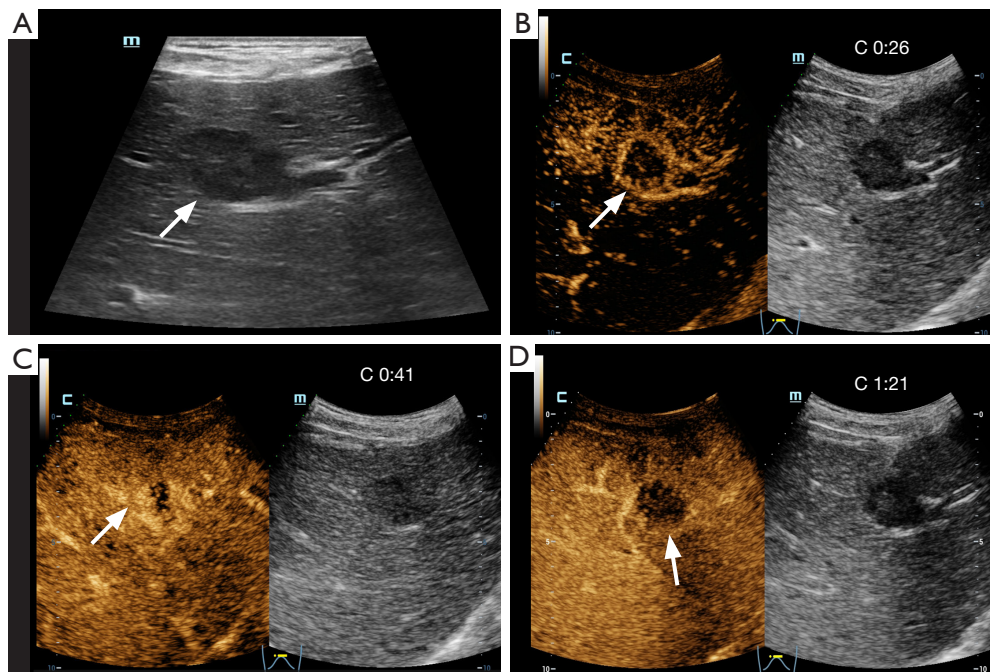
An LR-M lesion in a 58-year-old male patient with CHB. (A) A routine gray-scale ultrasound scan detected a 3.0 cm × 2.1 cm hypoechoic lesion in the left inner lobe of the liver, characterized by well-defined margins and regular shape (arrow). (B) The lesion exhibited rim hyperenhancement in the arterial phase of CEUS (arrow). (C) The lesion demonstrated hyperenhancement 41 seconds after contrast injection (arrow). (D) Marked washout (arrow) in the portal phase. The lesion was classified as LR-M, and pathological examination confirmed that it predominantly consisted of ICC, which was poorly differentiated. C, contrast timer; CHB, chronic hepatitis B; CEUS, contrast-enhanced ultrasound; ICC, intrahepatic cholangiocarcinoma.
